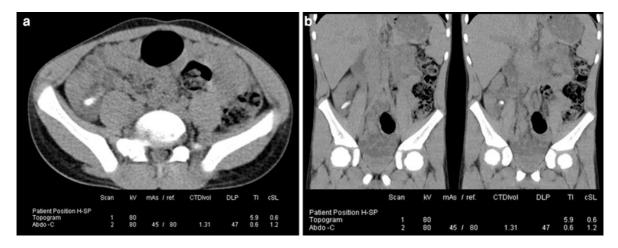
Unenhanced MDCT obtained at 80 kV in a 9-year-old boy weighting 34 kg after inconclusive ultrasound examination. Acute appendicitis is demonstrated by MDCT while
